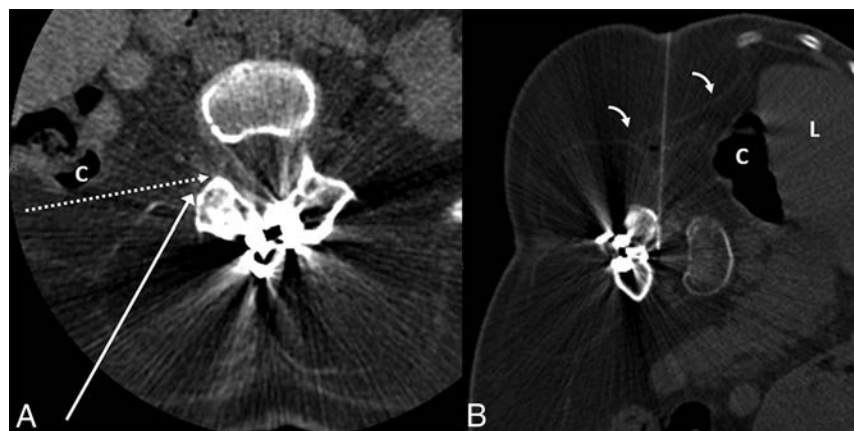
A 36-year-old woman with SMA2 (case 6). *A*, Preprocedural CT obtained in supine position at the level of L3–4 demonstrates extensive muscle atrophy. The *long white arrow* shows the normal needle trajectory for a transforaminal epidural steroid injection. The *dashed white arrow* indicates the needle trajectory for TFLP. Note that while supine, the posterior margin of the ascending colon (C) is along the proposed needle trajectory. *B*, CT fluoroscopy image during TFLP obtained with the patient in the left lateral decubitus position. The needle is advanced into the thecal sac with an angle slightly $>90^\circ$, just anterior to the facet. Note the anterior displacement of the liver (L) and ascending colon (C) in the decubitus position, providing a safer approach. Of note, the thin transversalis fascia (*bent arrows*) is well-visualized.
